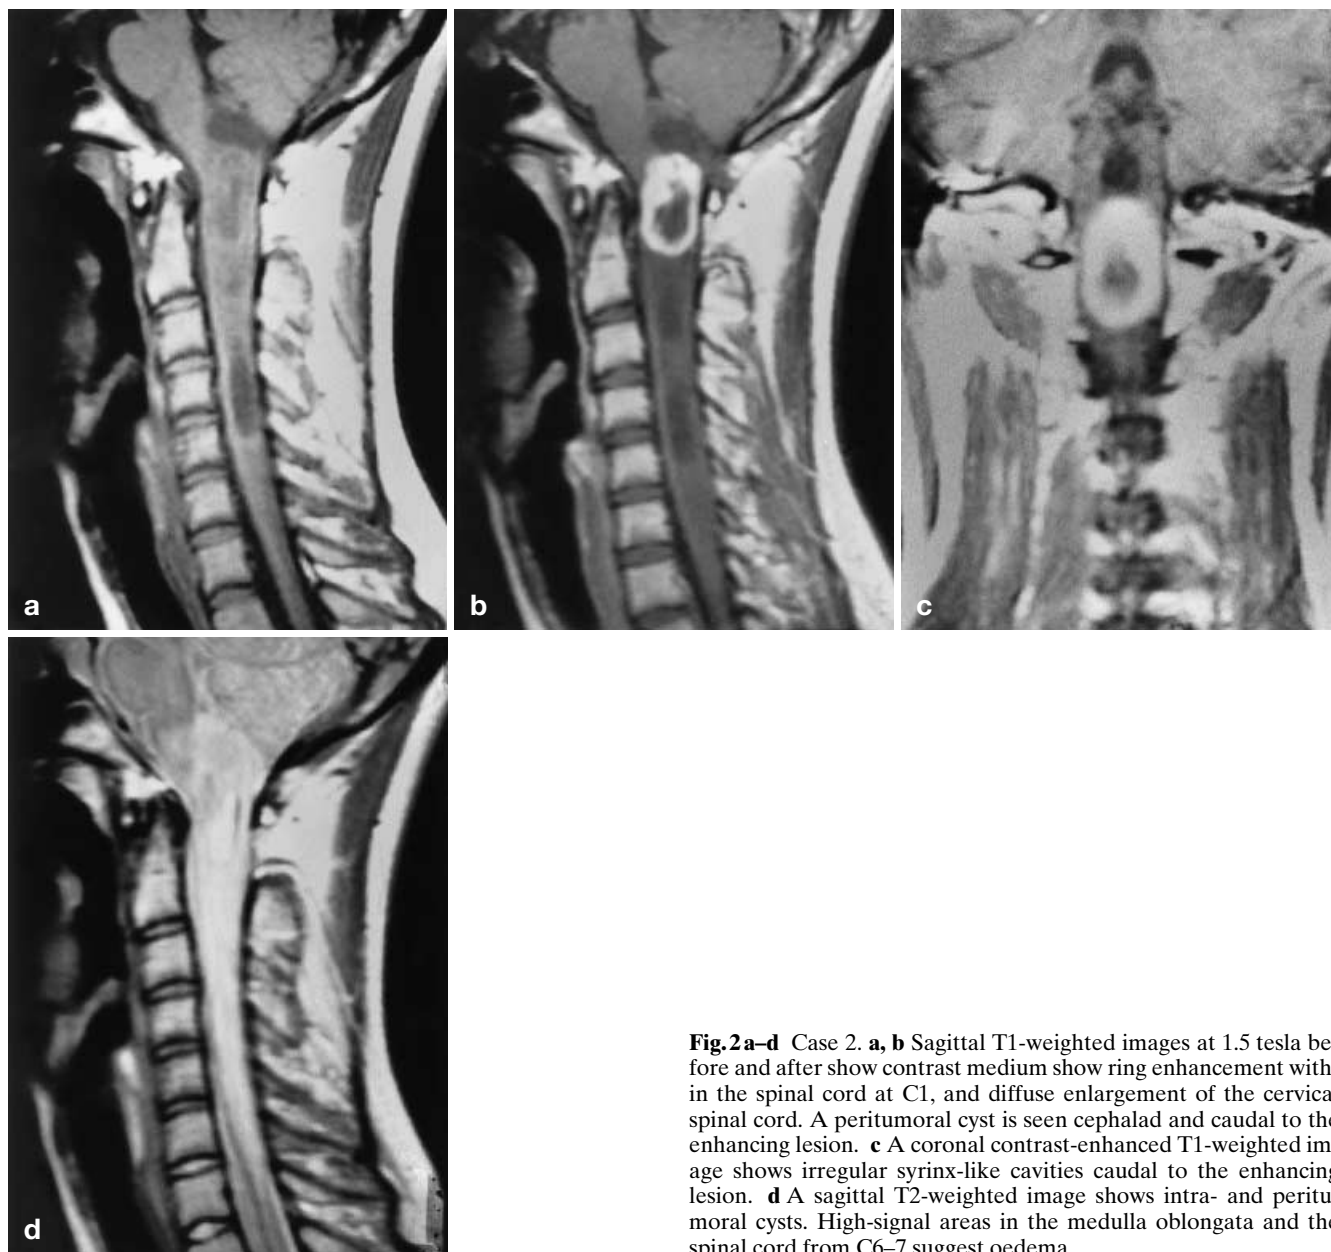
Case 2. a, b Sagittal T1-weighted images at 1.5 tesla before and after show contrast medium show ring enhancement within the spinal cord at C1, and diffuse enlargement of the cervical spinal cord. A peritumoral cyst is seen cephalad and caudal to the enhancing lesion. c A coronal contrast-enhanced T1-weighted image shows irregular syrinx-like cavities caudal to the enhancing lesion. d A sagittal T2-weighted image shows intra- and peritumoral cysts. High-signal areas in the medulla oblongata and the spinal cord from C6–7 suggest oedema
